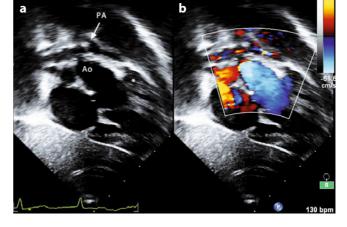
a Right subcostal anterior oblique view in tetralogy of Fallot demonstrating the antero-cephalad deviation of the outlet septum into the right ventricular outflow tract. Infundibular pulmonary stenosis (*asterisk*). Significant hypoplasia of the pulmonary trunk and pulmonary arteries. b Color Doppler imaging showing turbulence and flow acceleration in the right ventricular outflow tract. The turbulence continues into the pulmonary trunk and pulmonary arteries. *AO* aorta, *PA* pulmonary artery
